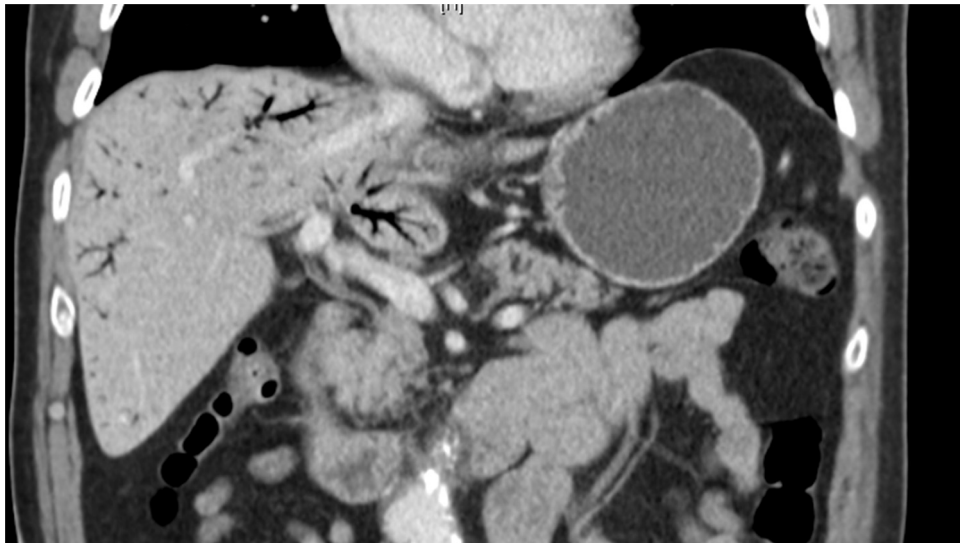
Pneumoportogram in the CT-scan.
